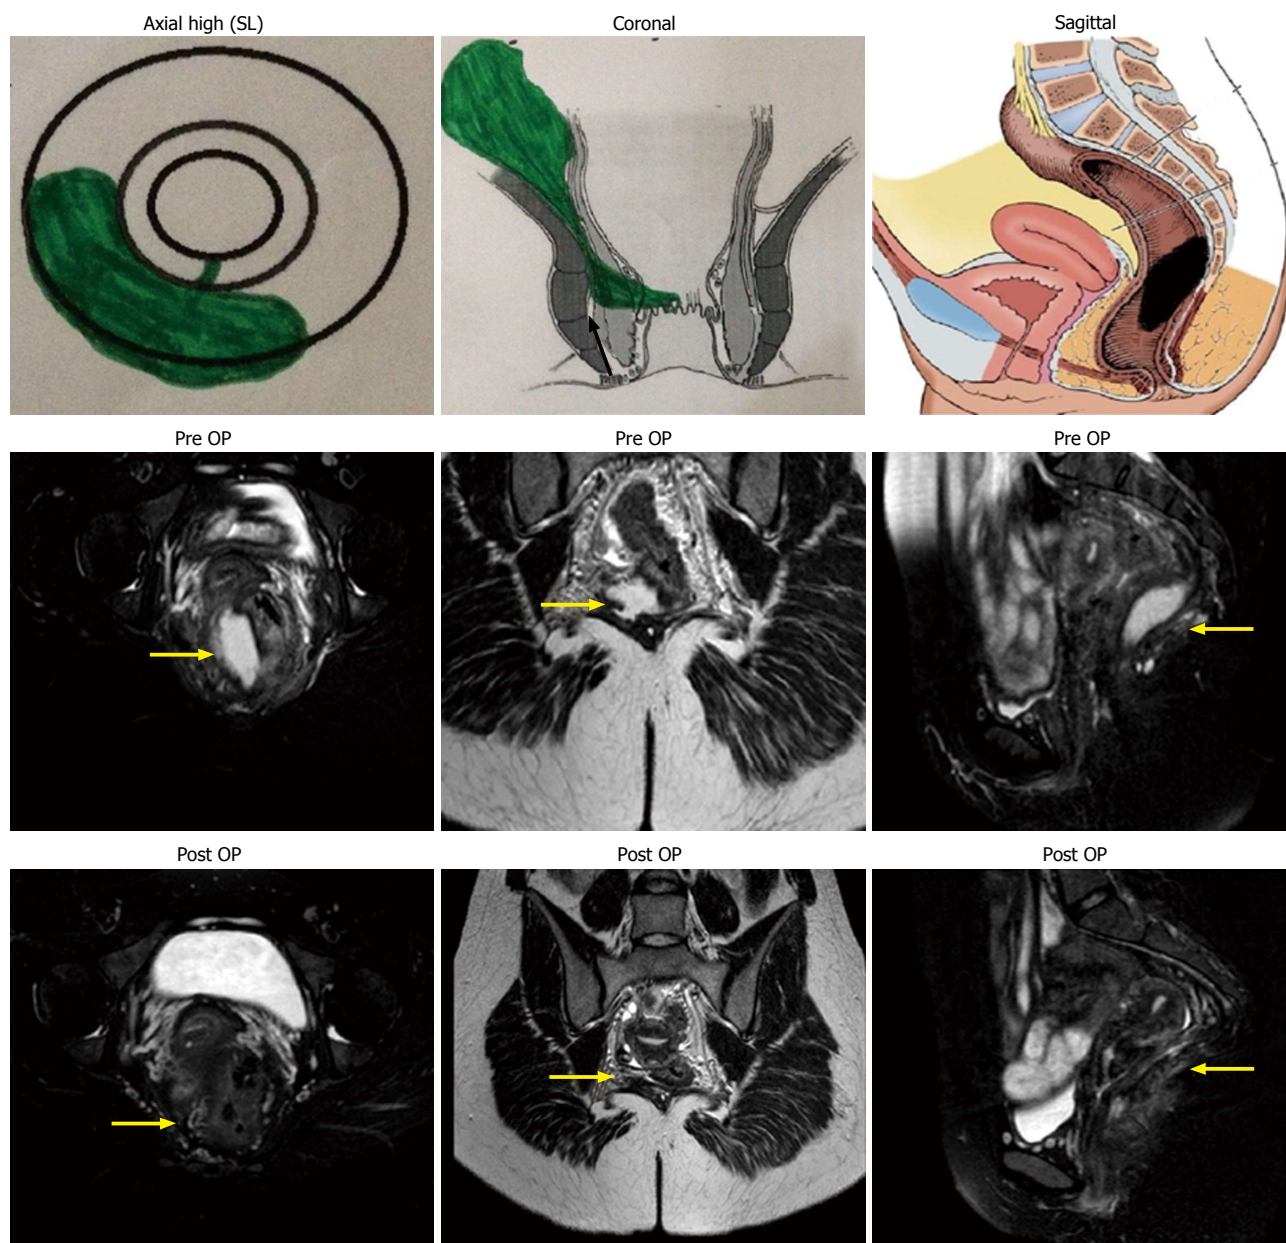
Intersphincteric supralelevator abscess and fistula. A 25-year-old female with supralelevator collection from 5 to 9 o'clock. Postoperative magnetic resonance images after 6 wk (bottom row) show complete disease resolution. SL: Supralelevator; OP: Operation.
